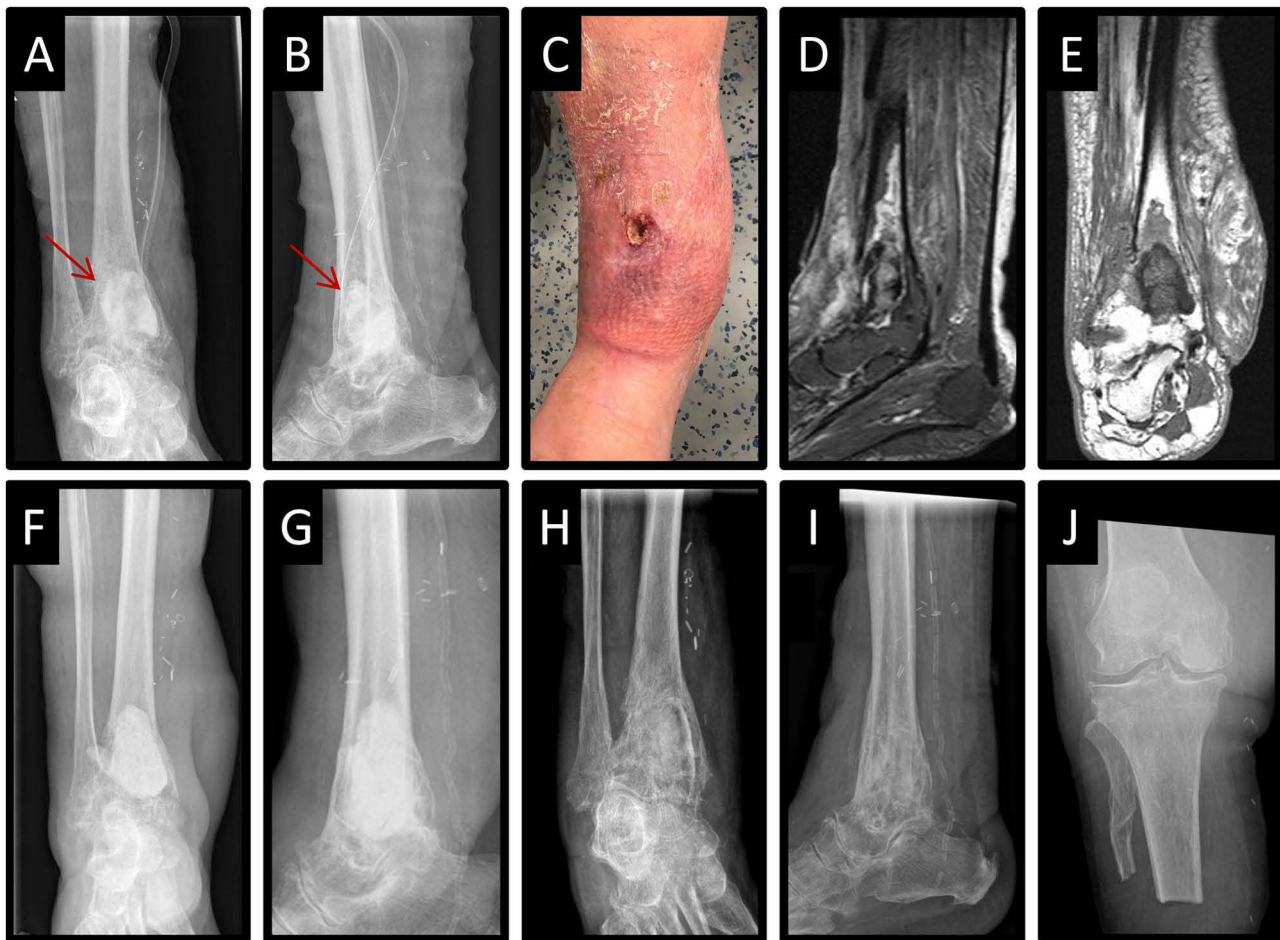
Case example of the treatment of osteomyelitis of the distal tibia in a 74-year-old female following ankle arthrodesis after an initial ankle fracture-dislocation. Staged Treatment with implantation of a cement spacer in the initial stage (AP view: (A), lateral view: (B)) and implantation of ALB+V in the definitive stage (red arrows; ap view: (C), lateral view: (D)). Recurrent infection with fistula formation 7 months postoperative (clinical image: (E); sagittal T2-weighted MRI: (F); coronal T1-weighted MRI: (G)). Two-stage revision surgery with autologous cancellous bone grafting in the second stage (ap view: (H), lateral view: (I)). Second recurrence leading to amputation due to persistent infection (J).
